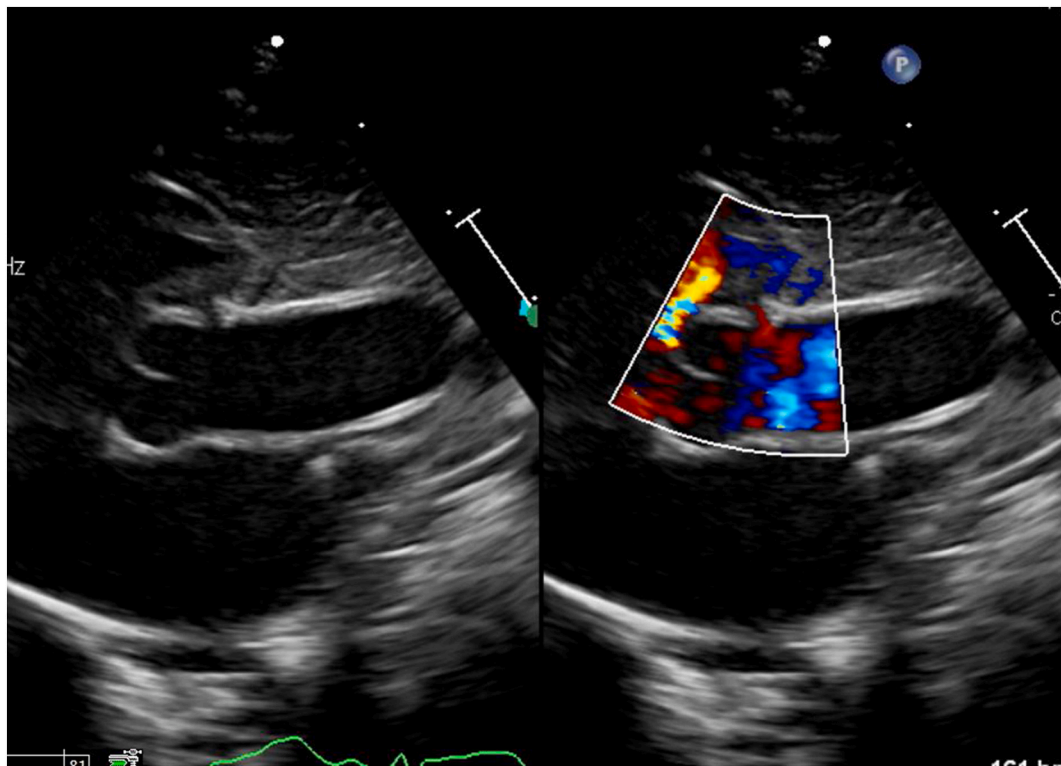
Normal level of origin of the right coronary artery as seen in the parasternal long axis view.
